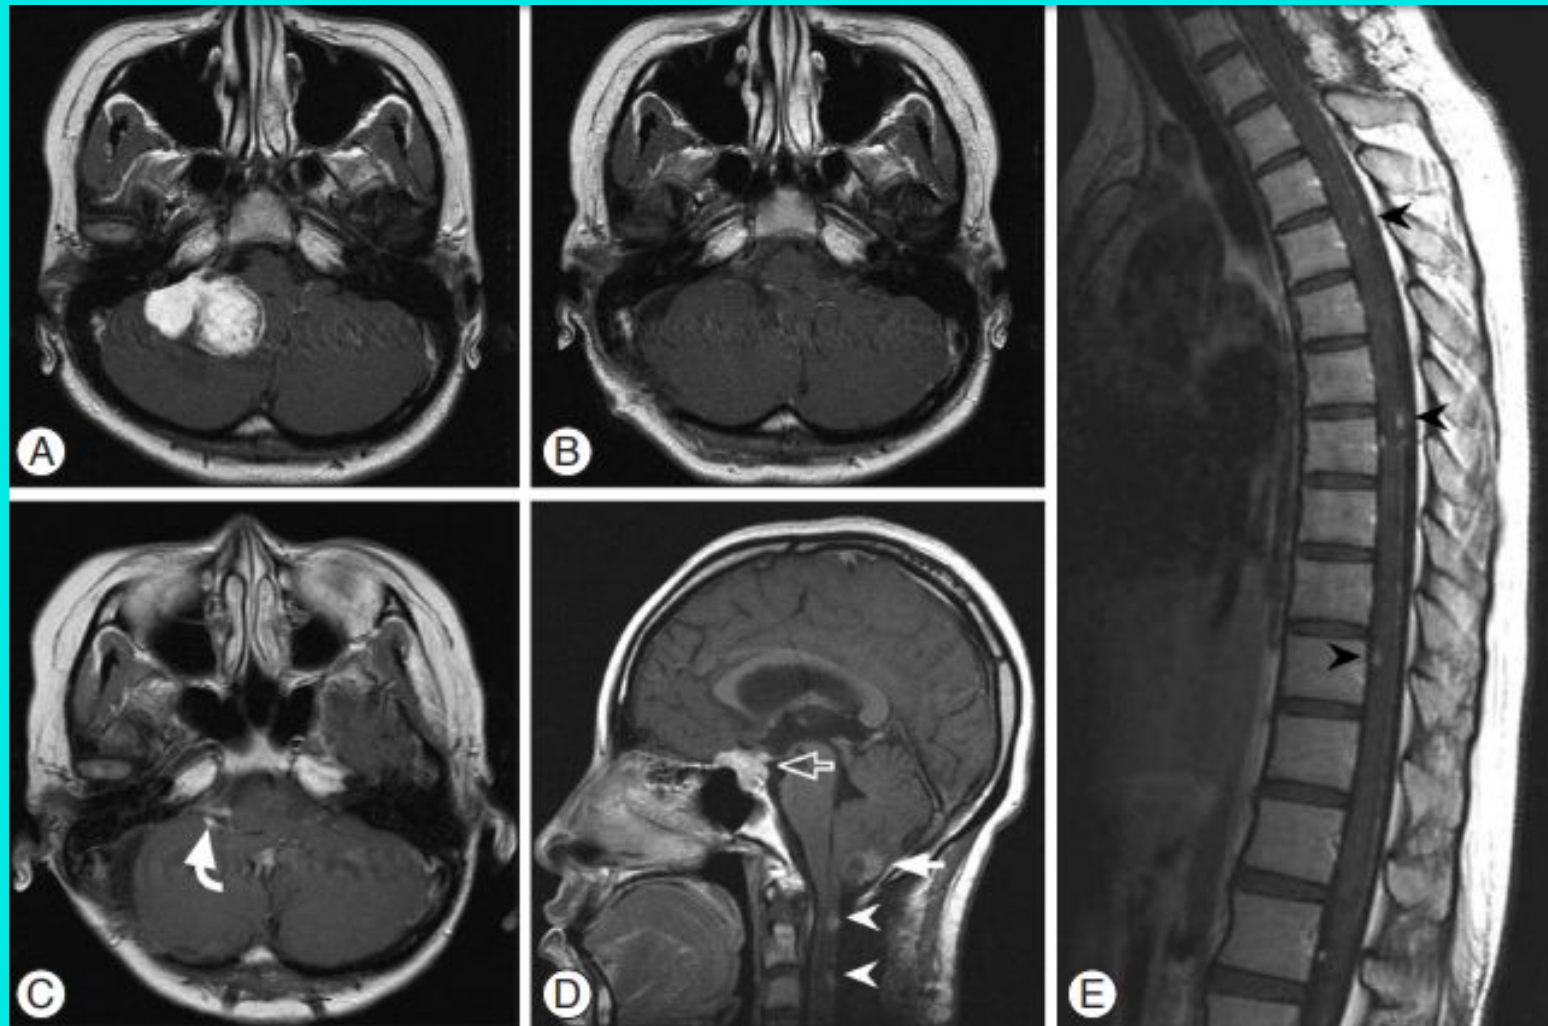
A : Preoperative enhanced magnetic resonance imaging (MRI) showing a right cerebello-pontine angle meningioma. B : Postoperative MRI displaying Simpson grade II resection of the tumor. C and D : Approximately 2.5 months later, follow-up MRI revealing the local recurrence (curved arrow) and new lesions in the posterior fossa (closed arrow), suprasellar (open arrow) and spinal region (arrowheads). E : Spinal MRI demonstrating multiple leptomeningeal disseminations (arrowheads).
